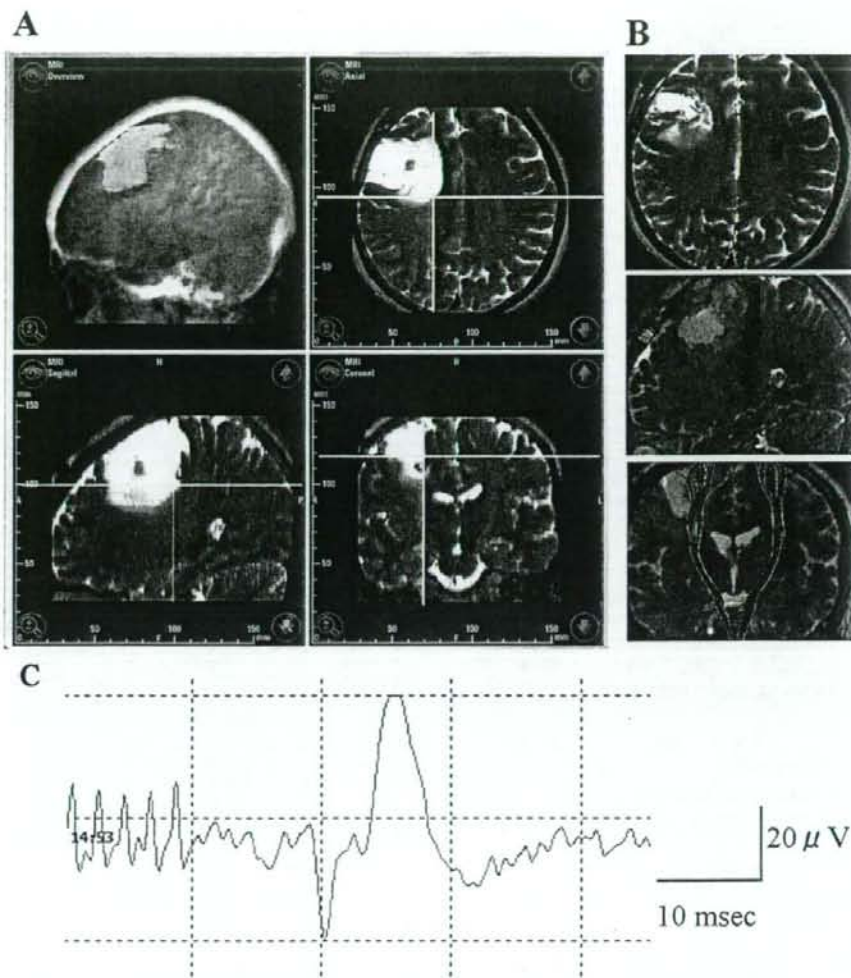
Subcortical MEPs elicited intraoperatively in a 36-year-old woman with a right frontal diffuse astrocytoma. Her neurological examination was normal preoperatively. A: Intraoperative T₂-weighted MR images showing a hyperintense area (yellow area in upper left panel) close to the pyramidal tract identified by fiber tracking (green). During the removal of the tumor, subcortical stimulation elicited MEPs at the bottom of the tumor (intersection of yellow lines) 8 mm from the edge of the estimated pyramidal tract. No further removal was performed to avoid causing neurological deficits. B: Post-operative MR images demonstrating that the pyramidal tracts identified by fiber tracking (red) are preserved. C: A typical waveform of MEP response elicited from the left biceps muscle by subcortical stimulation during tumor removal.
